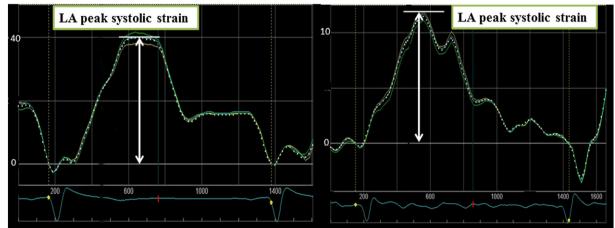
Measurement of LA peak systolic strain. LA strain was estimated by averaging the longitudinal strain data obtained from the apical four-chamber, two-chamber and apical long-axis views. The LA myocardium was divided into five regions of equal area. Five segments were analyzed from the apical four- and two-chamber views, whereas only three segments were analyzed in the apical long axis view. LA, left atrium. We show good LA strain with sinus rhythm in Fig. 1B and bad LA strain with atrial fibrillation (Fig. 1C).
